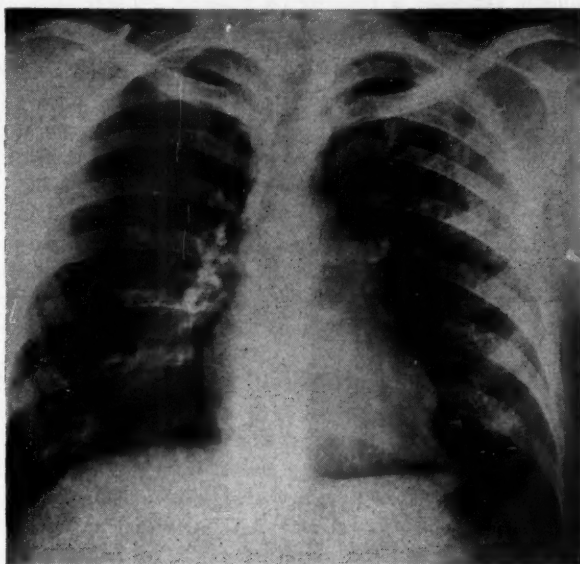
Photograph of chest x-ray 3 months postoperatively showing almost complete disappearance of pulmonary lesion.
